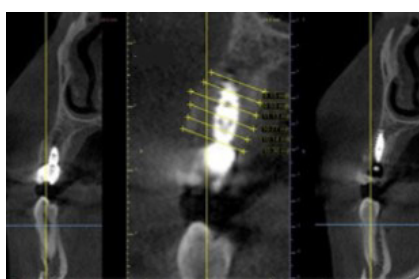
Post-Operative CBCT measurement at bone crest level, and every other 2mm apically till 10mm, and alveolar bone bucco-palatal change in cross section views
